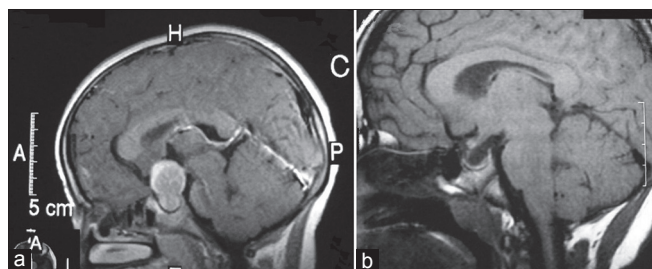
(a) (February 2009) T1W MRI brain showing pituitary macroadenoma with predominant suprasellar extension. (b) (January 2012) T1W MRI brain showing empty sella with absent posterior pituitary signal
